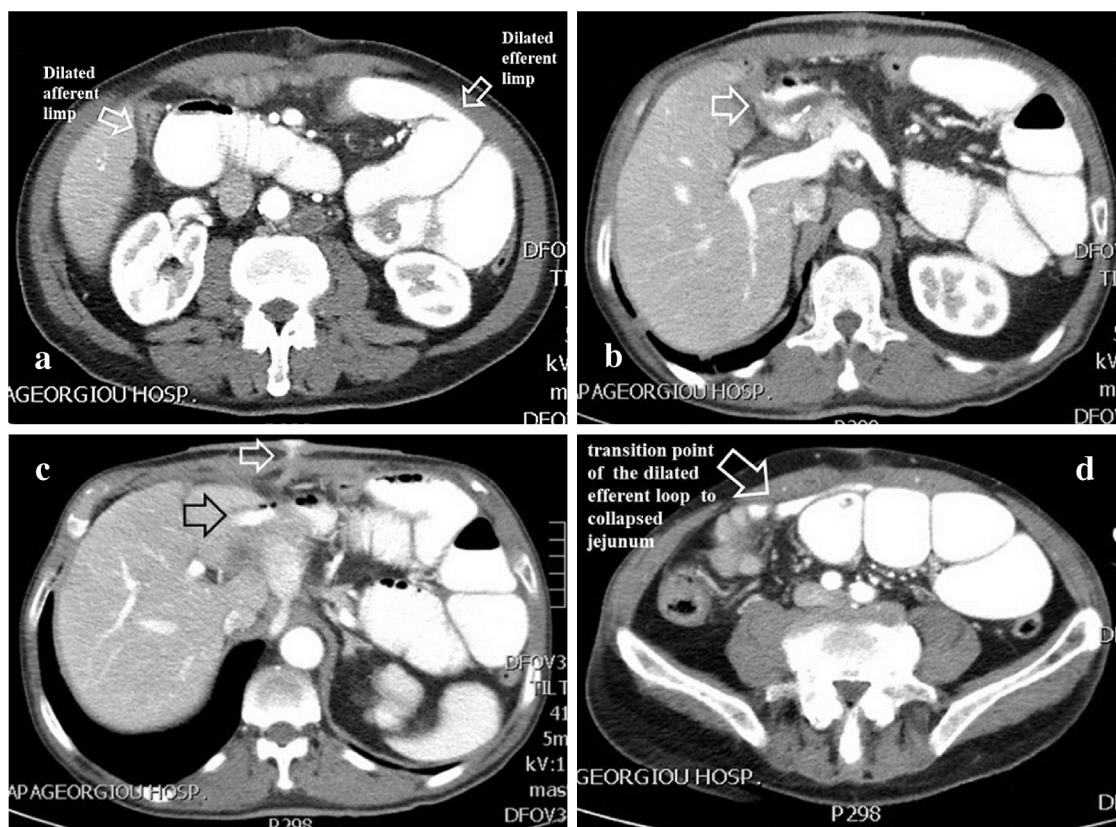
(a) Multidetector CT scan shows excessive dilatation of the afferent and efferent limbs to the jejunojejunal anastomosis. The afferent limb is opacified by oral contrast while the jejunojejunal anastomosis was intact with no leak of positive oral contrast. (b) Multidetector CT scan depicting a right subhepatic fluid collection surrounding the duodenal stump's staple line infiltrated with air densities (white arrow) suggestive of a DDS. (c) The right subhepatic fluid collection surrounding the DS staple line (black arrow) corresponding to the extravasated oral contrast which is extruding (white arrow) through a small dehiscence in the upper pole of the upper midline surgical wound. (d) The dilated efferent loop is depicted to have a transition point to collapsed jejunum at approximately the level of jejunoileal junction.
